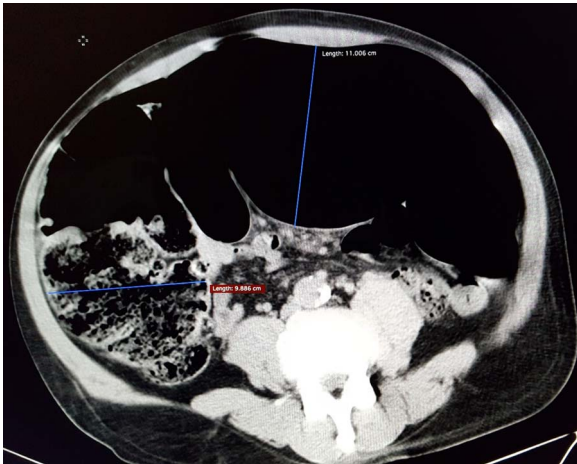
CT scan abdomen showing dilated large bowel, maximum transverse diameter 11 cm with collapsed small bowel.
